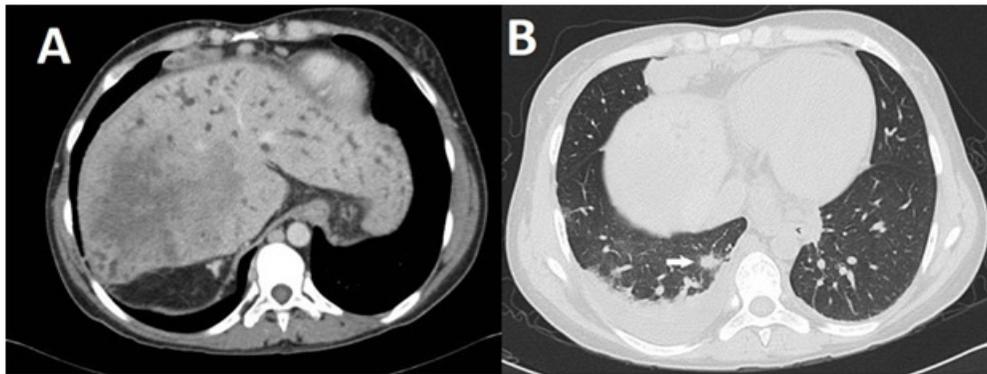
Abdominal and thorax computed tomography. (A) Liver with hypertrophy of the left lobe, with irregular borders and with a hypodense and heterogeneous lesion located in 8 and 7 segments. Dilatations of intrahepatic biliary ducts with saccular dilatations were also found. (B) Pulmonary nodule of 1.4 cm in the right inferior lobe (white arrow).
